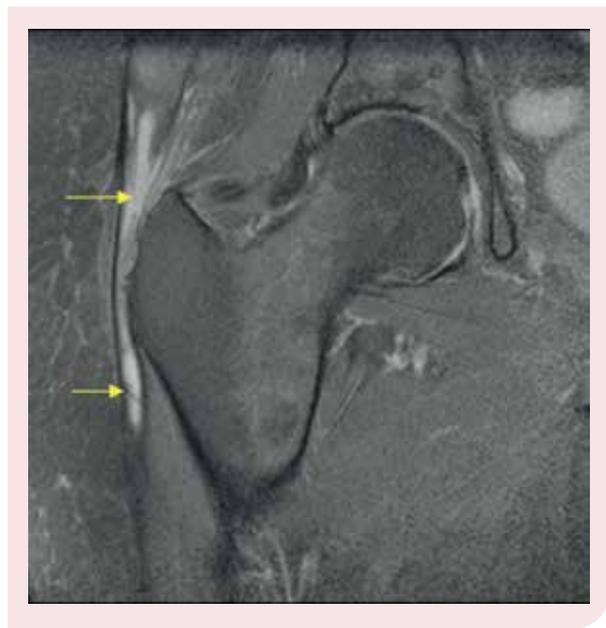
Coronal PD weighted MRI image with fat saturation of the right hip demonstrating bright fluid distending the greater trochanteric bursa (arrows).
